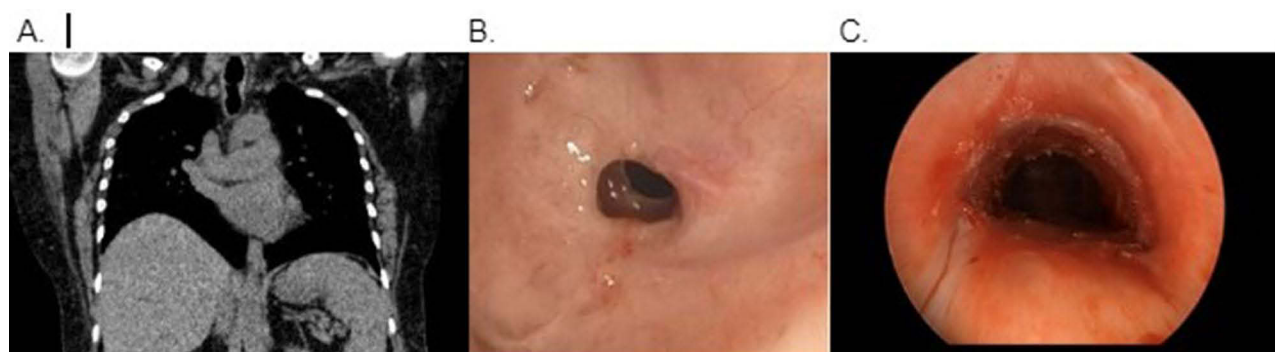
Grade 3, complex corkscrew-type stenosis which extended 3 tracheal rings seen on CT chest (A) and pre-dilation bronchoscopy (B). Post-dilation bronchoscopy reveals airway patency (C).
